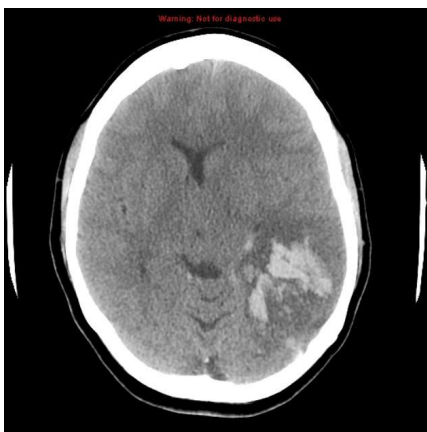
Non-contrast CT of the brain demonstrates intracerebral hemorrhage involving the left parieto-occipital region as well as superior temporal lobe, which is heterogeneous and gyriform(Jones et al., 2016).
